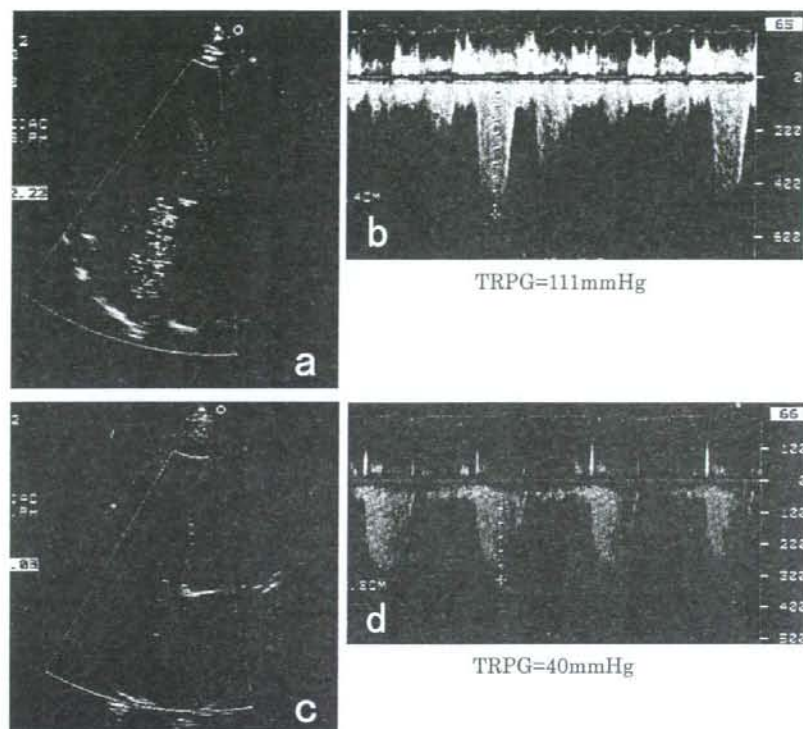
Doppler echocardiograms from a woman with severe mitral stenosis
